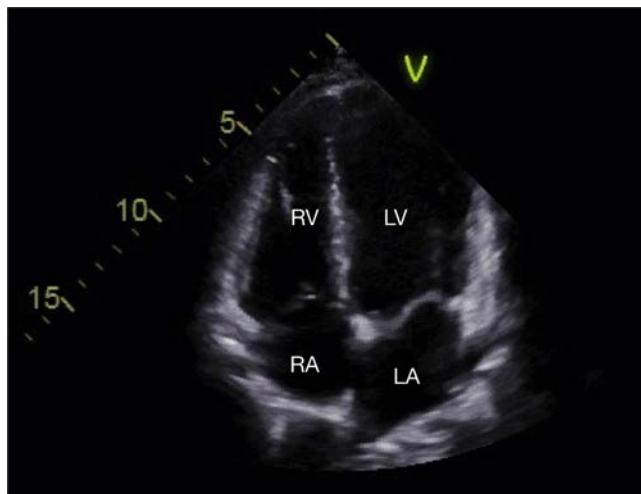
Transthoracic apical four-chamber view. This view is analogous to the midesophageal four-chamber view in transesophageal echocardiography. *LA*, Left atrium; *LV*, left ventricle; *RA*, right atrium; *RV*, right ventricle.
